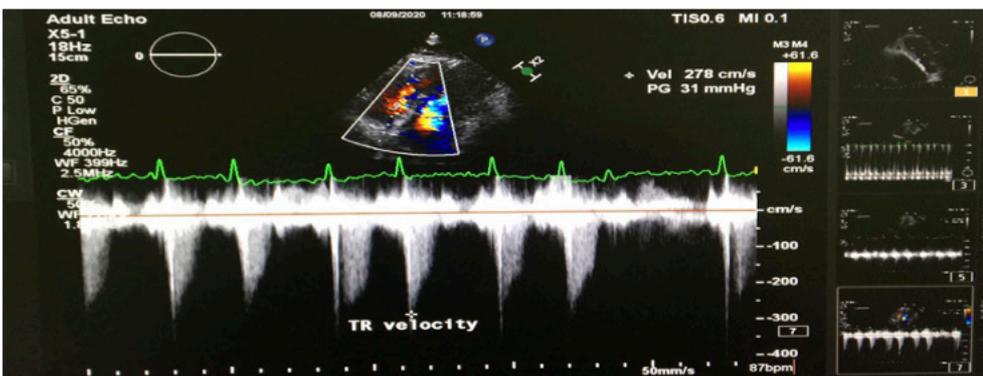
In the continued wave doppler evaluation obtained from the tricuspid regurgitation jet flow, the tricuspid regurgitation peak jet velocity was detected as 2.8 m/sec.
